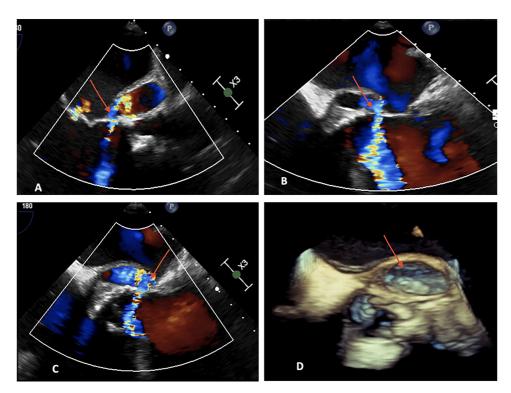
Transesophageal echocardiography (TEE). Perivalvular cavity around the aortic root communicating with the aorta, with presence of retrograde blood flow resulting in severe (4+) aortic valve regurgitation. (A) Midesophageal long-axis view with color Doppler showing significant blood flow from the ACF to the left ventricle cavity. (B and C) Midesophageal five-chamber view with color Doppler showing significant blood flow from the aortic root to the ACF. (D) 3D transesophageal echocardiography with visualization of the ACF.
